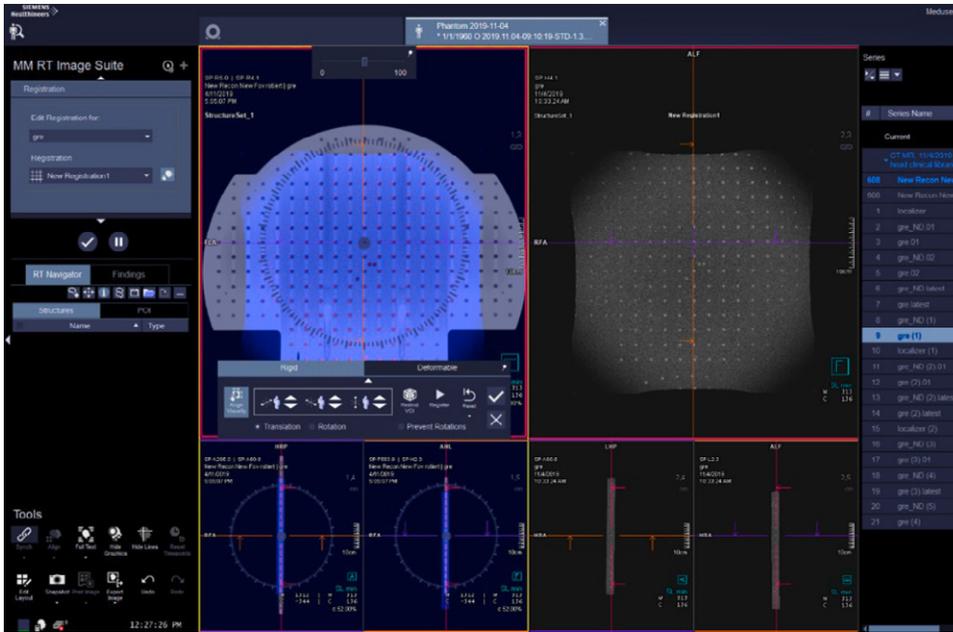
Rigid registration within syngo.via RT Image Suite, of MR and CT images, for visual comparison
